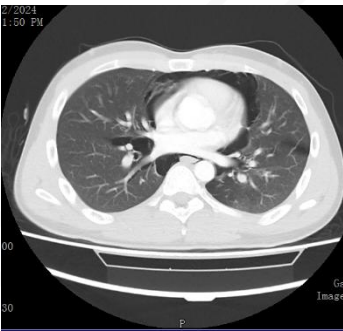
CT Thorax showing extensive pneumomediastinum with subcutaneous emphysema
